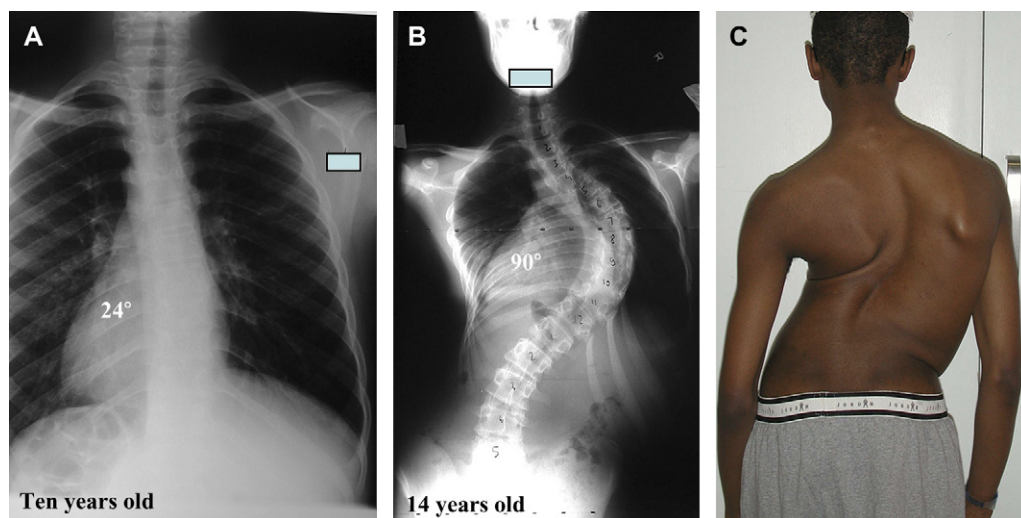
Progression of a 24° curve in a 10-year-old boy without treatment. (A) Standing radiograph of the 10-year-old patient with a 24° curve. (B) Standing radiograph of the same patient after 4 years with a 90° curve. (C) Clinical photograph of the patient shows severe spinal deformity after 4 years without any treatment.
